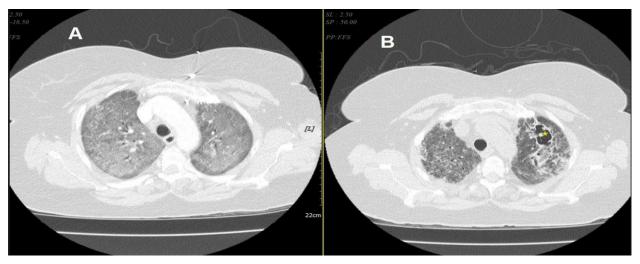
Comparison Computed tomographic (CT) scan of the chest confirming early COVID -19 Pneumonia without (A) and with (B) pneumatocele (star).
